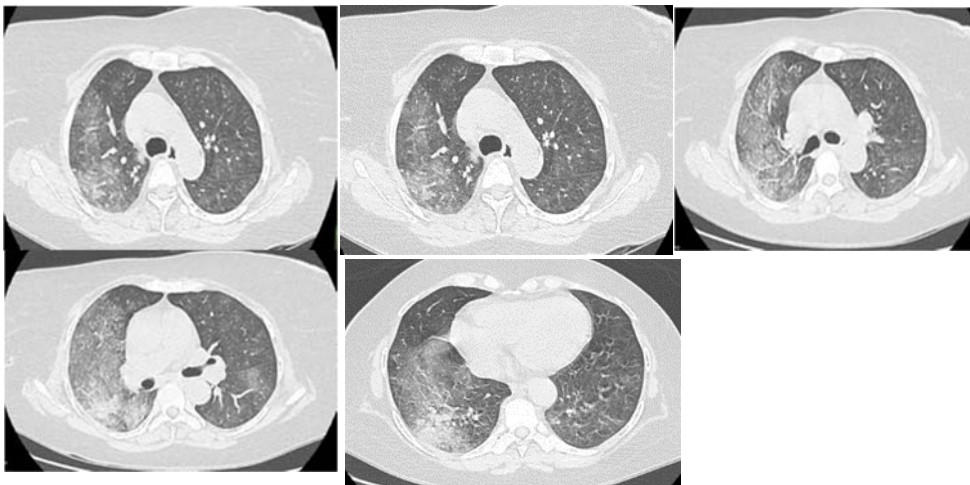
Axial lung windows of the high-resolution chest CT scan (was done on first clinic visit) revealed predominantly right middle and lower lung fields alveolar fillings with ground-glass opacification and some patchy area in left lung GGO.
